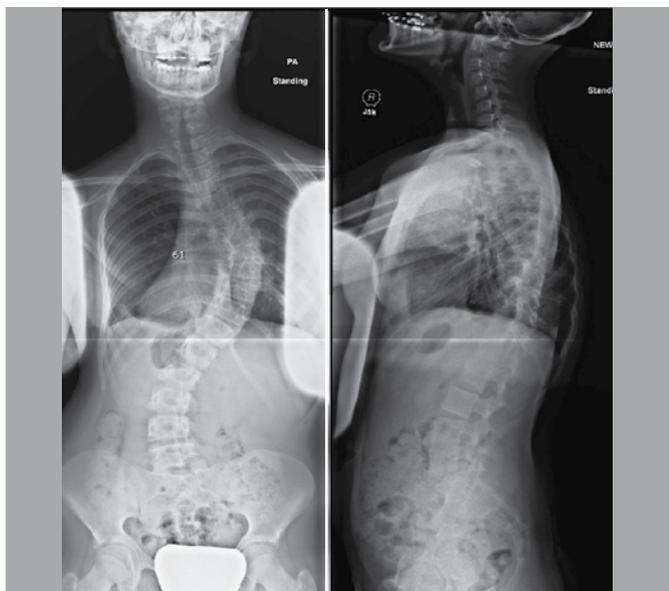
Coronal and sagittal radiographs of a 14 year-old female with 61° preoperatively.
